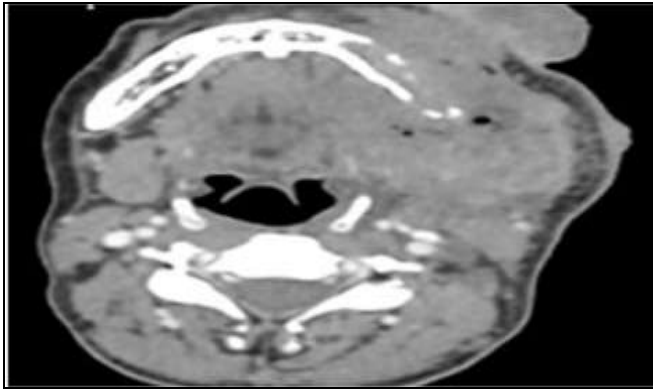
Axial Images of Contrast-Enhanced CT Scan of Oral Cavity Soft Tissue Window Highlighting the Soft Tissue Mass Lesion in The Left Bucco-Gingival Sulcus With Local Extensions in Adjacent Soft Tissues
